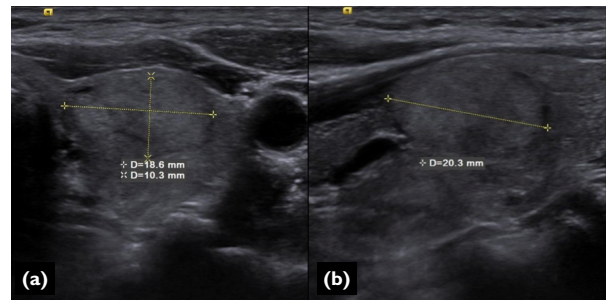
Anteroposterior and mediolateral dimension measurements on horizontal (a) and craniocaudal on vertical (b) aspects of transcervical ultrasound.
